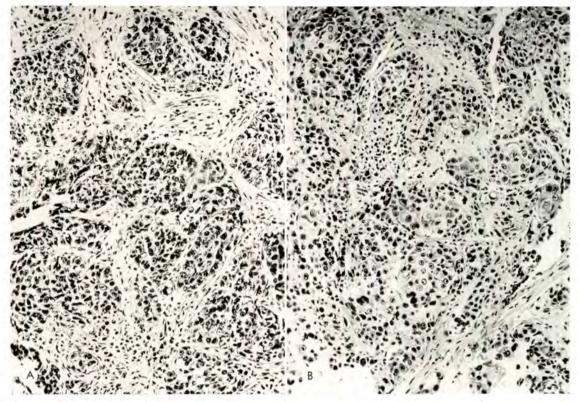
Tissue sections. RST moderate. Cancer of the cervix, Stage ic. Treatment: Transvaginal cone therapy, radium, external roentgen irradiation. Died of disease i year later. (A) H & E control, ×207. (B) H & E, ×207 (7 days after 3,000 r by transvaginal cone).
